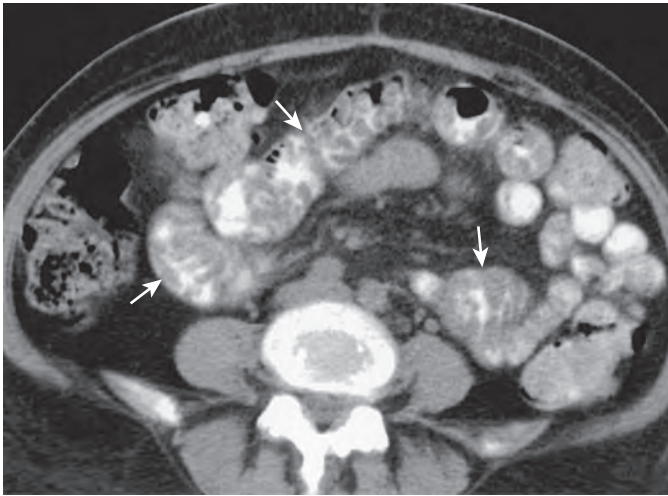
Graft-versus-host disease. CT through the top of the iliac crest shows extensive fold thickening (arrows) in mid small bowel loops.
